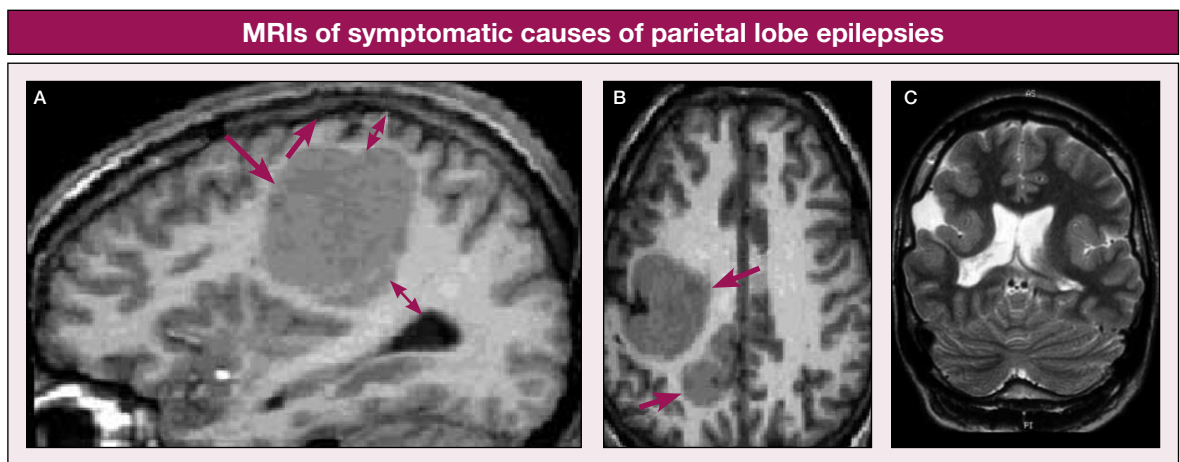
(A) Coronal and axial T1-weighted MRI demonstrating parietal subcortical heterotopia (arrows). (B) Coronal T2-weighted MRI demonstrating bilateral perisylvian polymicrogyria. (C) Coronal inverted T2-weighted MRI demonstrating abnormal signal changes (post-traumatic in nature) in the left parietal lobe involving the white matter.
